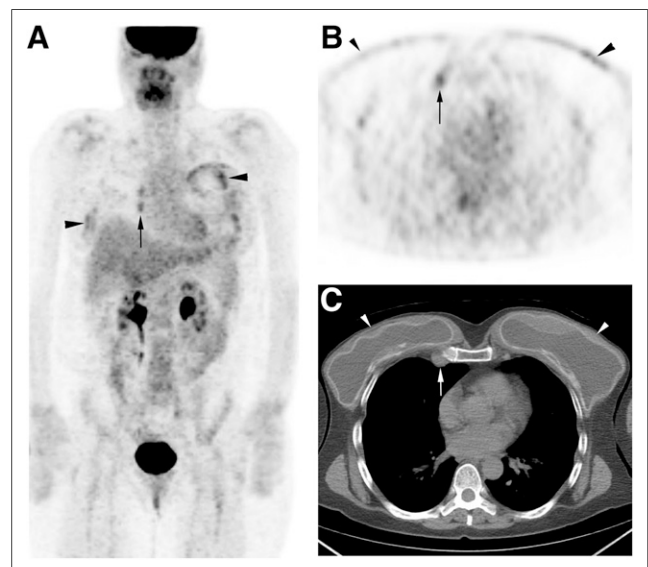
(A and B) Maximum-intensity projection (A) and axial (B) ¹⁸F-FDG PET images show patchy activity around breast implants, on left more than on right (arrowheads), and hypermetabolic right internal mammary nodes (arrows). (C) Axial unenhanced CT component of PET/CT image at level of breasts shows bilateral wavy contour of breast implants (arrowheads), suggesting rupture, and enlarged right internal mammary node (arrow).
